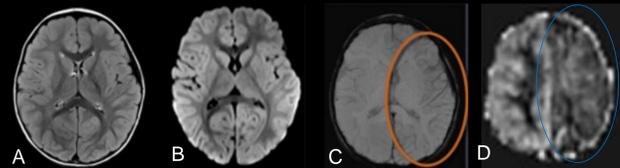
2-year-old boy with headache found to be neglecting one half of a page while coloring. Axial FLAIR (A) and DWI (B) images were normal and SWI demonstrated subtle asymmetric increase oxygen extraction in left cerebral hemisphere (C). PASL image (D) demonstrated reduced perfusion throughout the left cerebral hemisphere. Imaging and clinical diagnosis consistent with hemiplegic migraine.
